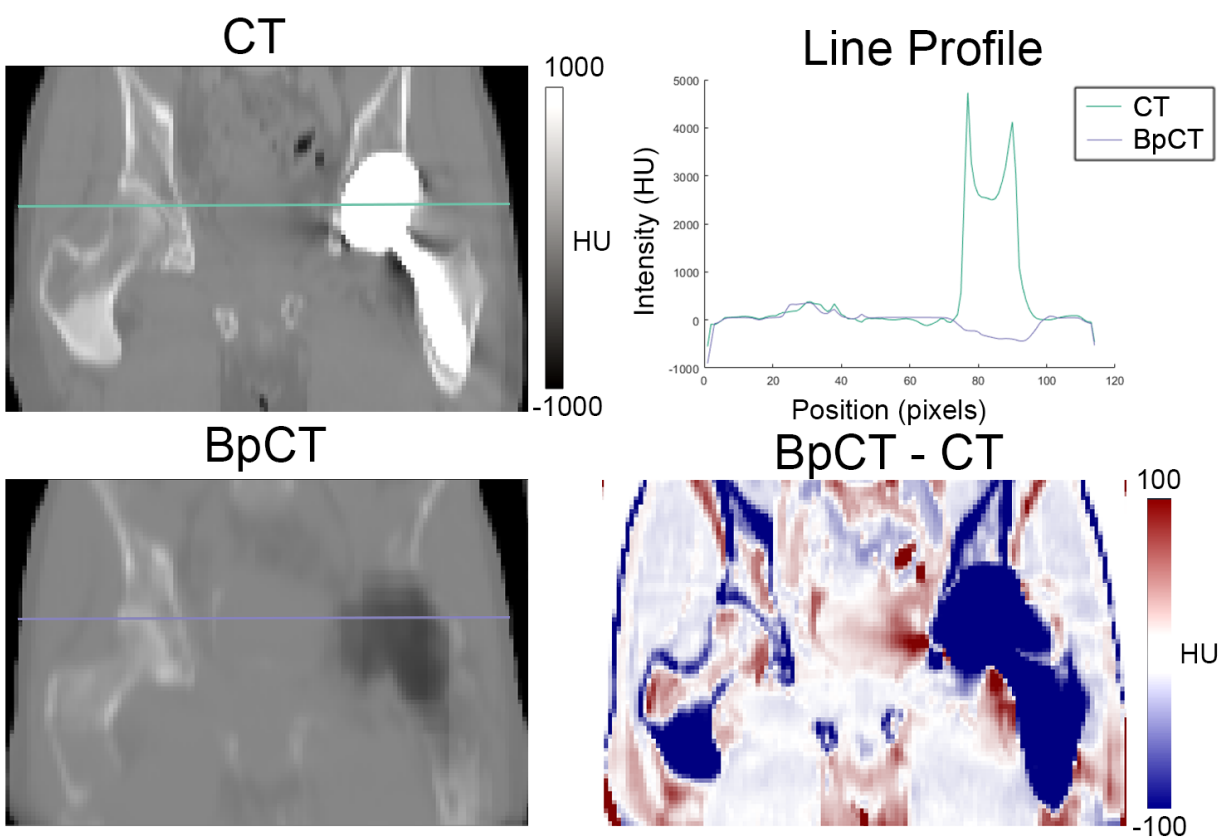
CT, pseudo-CT, line profiles, and difference images for a patient with a metal implant imaged with PSMA.
